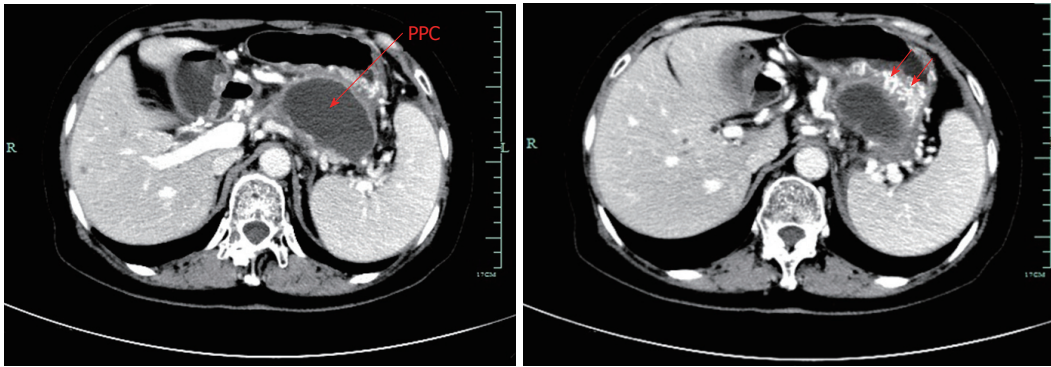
Pre-procedural contrast-enhanced computed tomography image. Computed tomography (CT) scan of the upper abdomen images revealed a 7.4 cm × 6.2 cm pancreatic pseudocyst in the tail of the pancreas, which was in close contact with the posterior wall of the stomach. Notably, splenic vein occlusion, splenomegaly and gastric varices were also observed.
